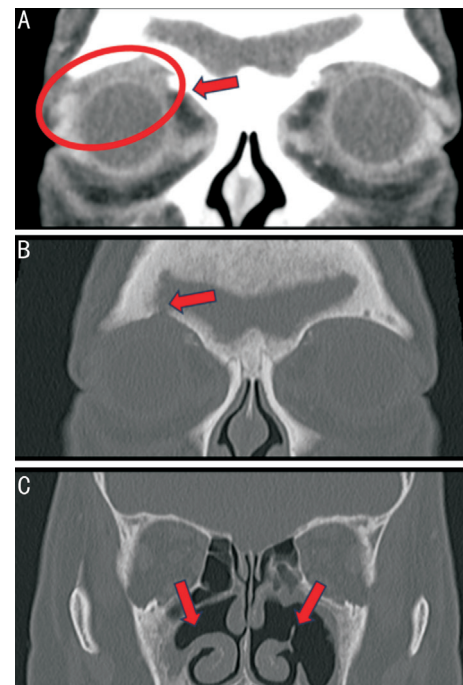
Coronal contrast-enhanced CT (3mo after commencing therapy) A, B: The orbital mass lesion has significantly reduced in size; C: Bone destruction has remained. CT: Computed tomography.
